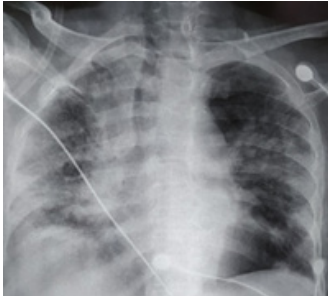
Chest radiograph on the day of admission, showing poorly defined pulmonary opacities bilaterally, located principally in the middle and lower lung fields.
